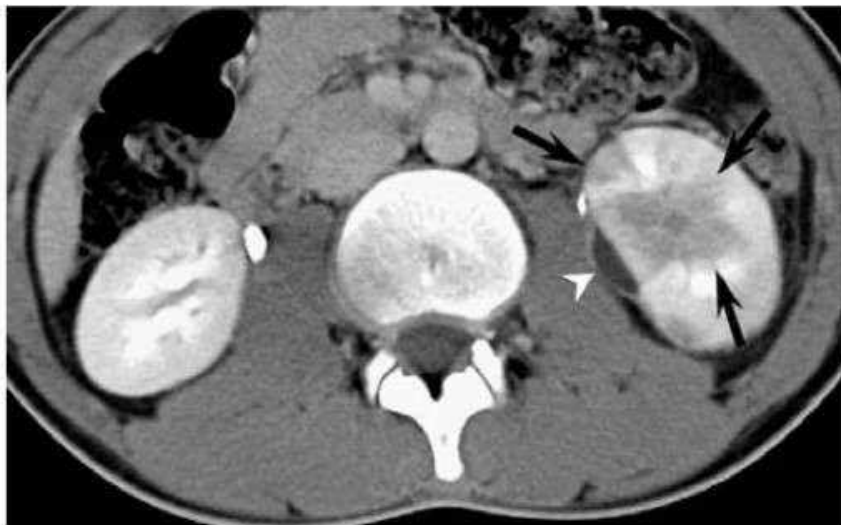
Grade 2 renal trauma on CT
